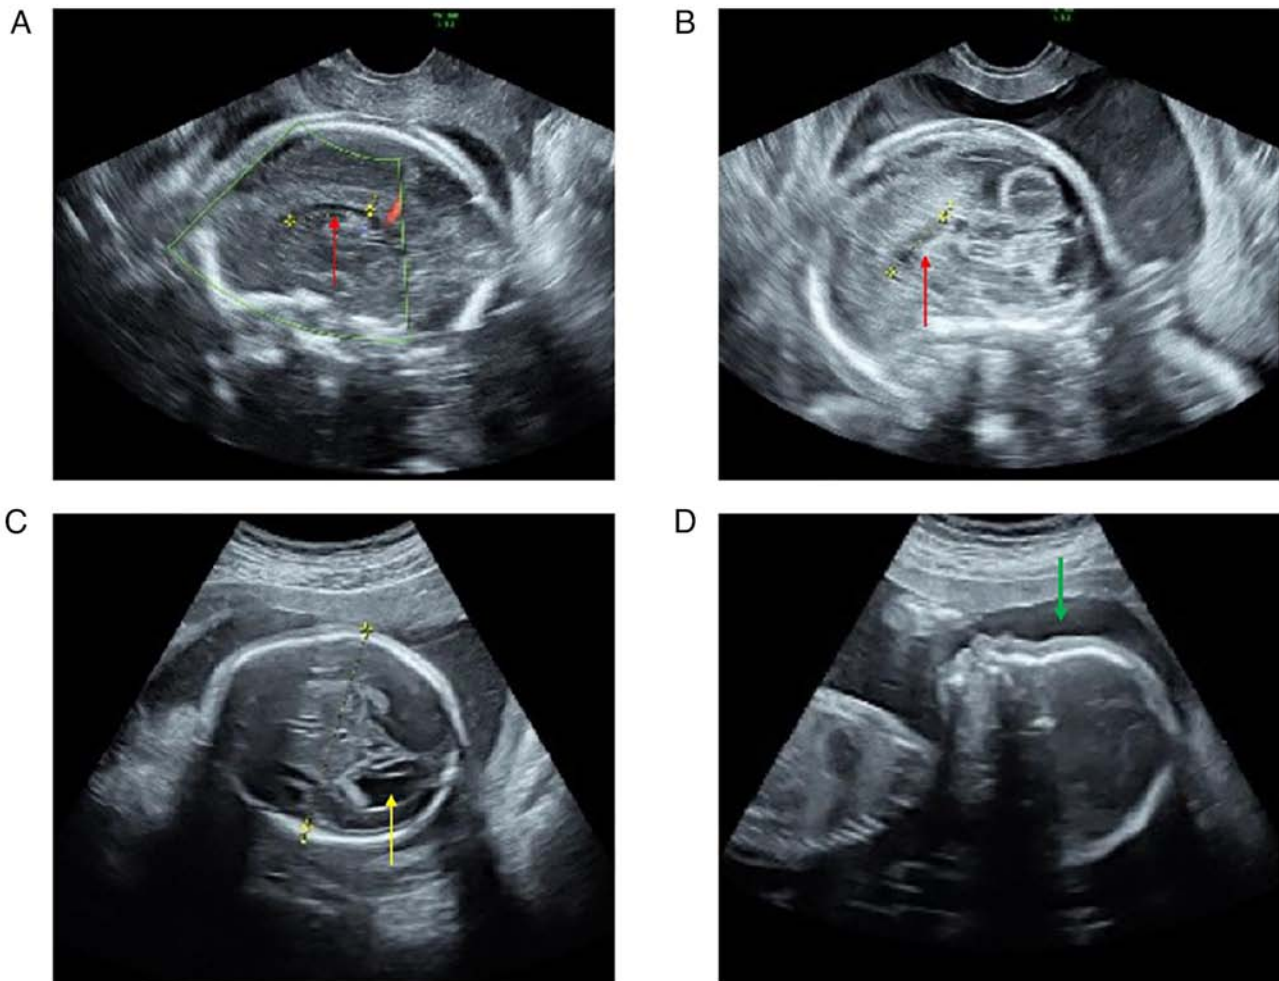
Ultrasound evidence of clinical features of fetus. (A) Red arrows show the corpus callosum dysplasia, which presents as thin. (B) Red arrows show the corpus callosum dysplasia, which is not clearly visible. (C) Axial view of fetal cerebral ventriculomegaly (yellow arrow). (D) Sagittal view of the fetal face shows a flat forehead and facial profile.
